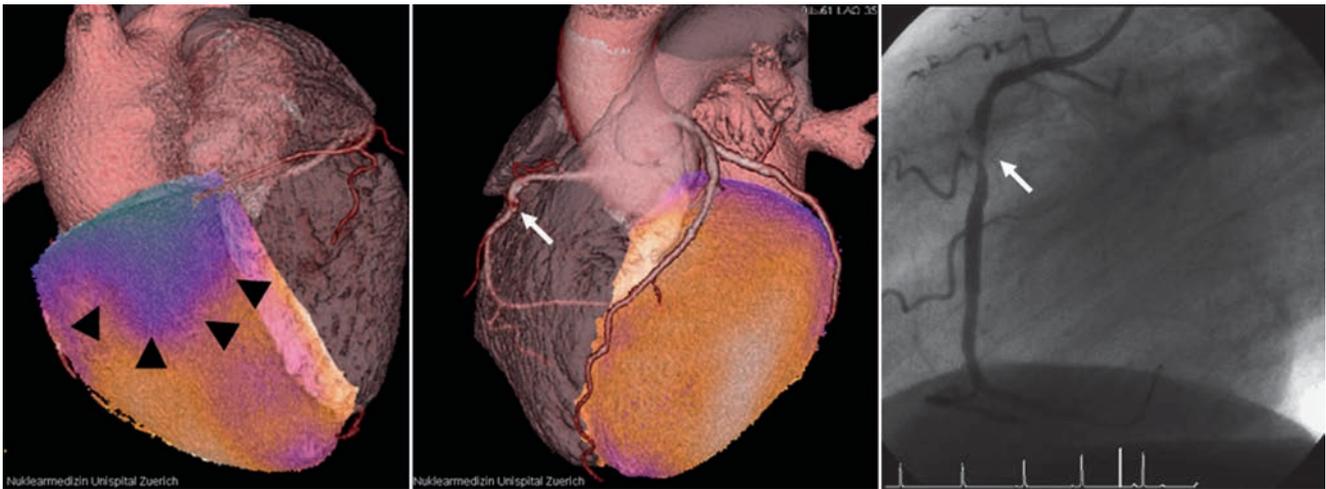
Three-dimensional cardiac hybrid SPECT-CT image: a volume rendered CT coronary angiography image is fused with the stress perfusion SPECT. The *left panel* shows a basal inferior ischaemic area (blue area, black arrow heads). The *middle panel* reveals a lesion
